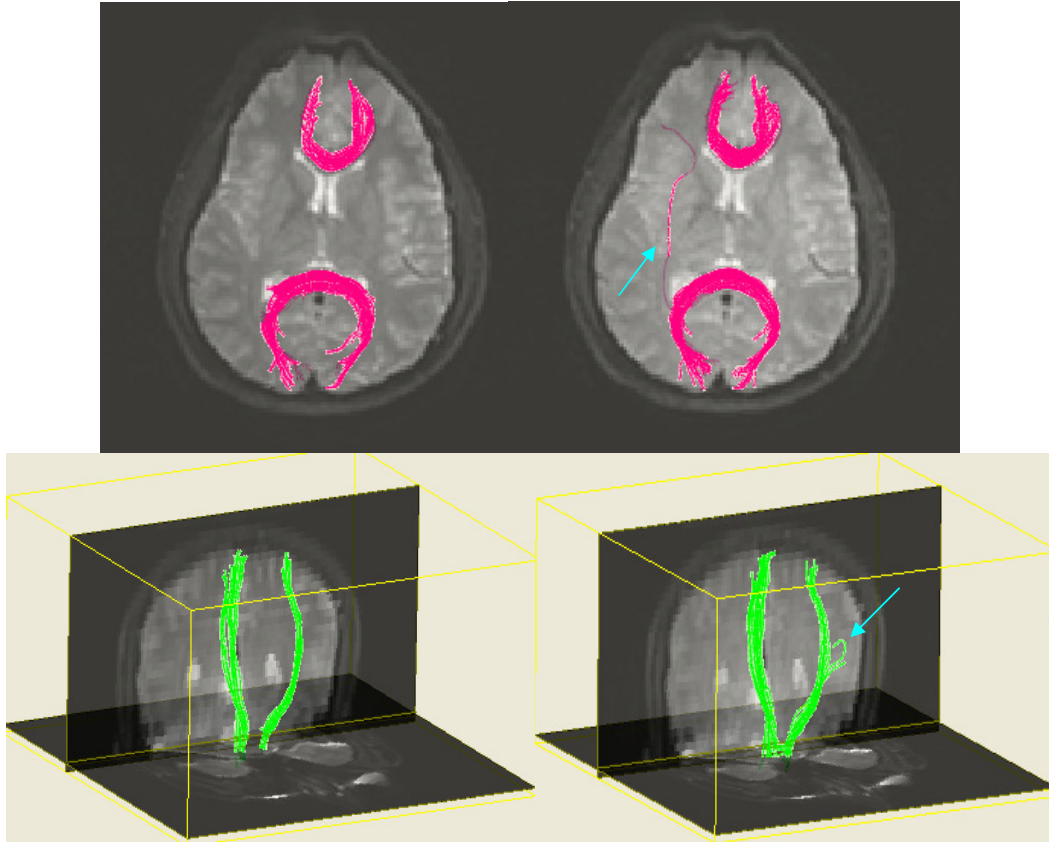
Cardiac-gated (left) and Non-cardiac-gated (right) DT-MRI evaluation for one subject. U-fibers (pink) and fibers belonging to the corticospinal tract (green) are shown. Spurious fibers (marked with blue arrows) seen for the non-cardiac gated data.
